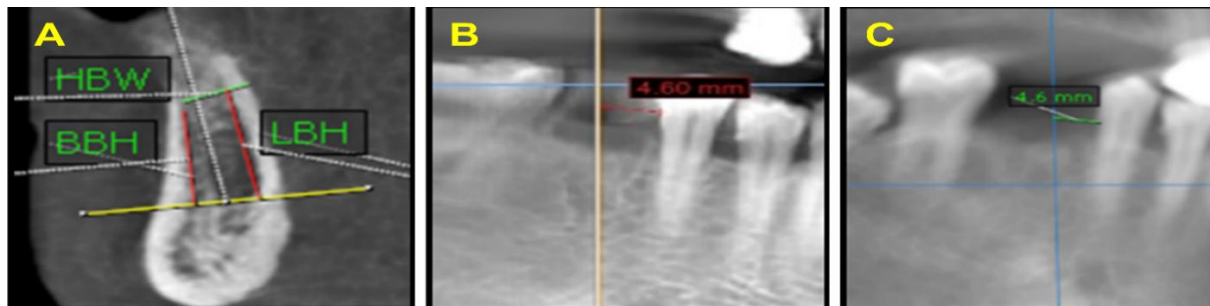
A) the reference line of CBCT measured before and after 4 months of extraction; B) the reference line of the CEJ of adjacent last tooth (before); C) the reference line of the CEJ of adjacent last tooth (after).
